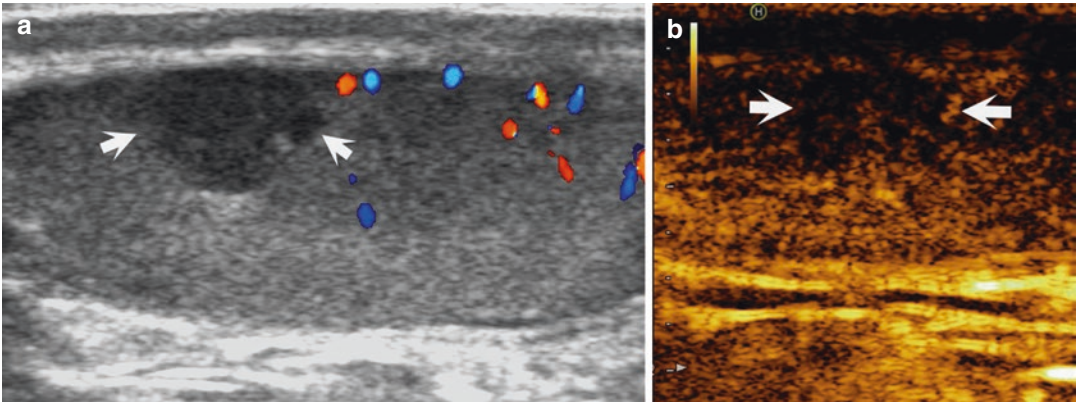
Segmental testicular infarction. Color Doppler image shows a hypoechoic nonvascular lesion (*white arrows*) (a). After contrast injection, the lesion (*white arrows*) shows no enhancement confirming its avascular nature (b)
